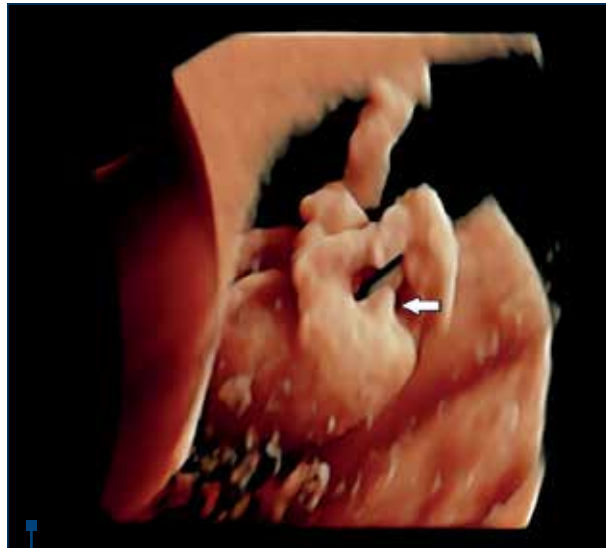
Three-dimensional ultrasound image of a 10+1 weeks fetus. Note the white arrow pointing to the genital tubercle. Source: R.E. Bohiltea – personal collection
